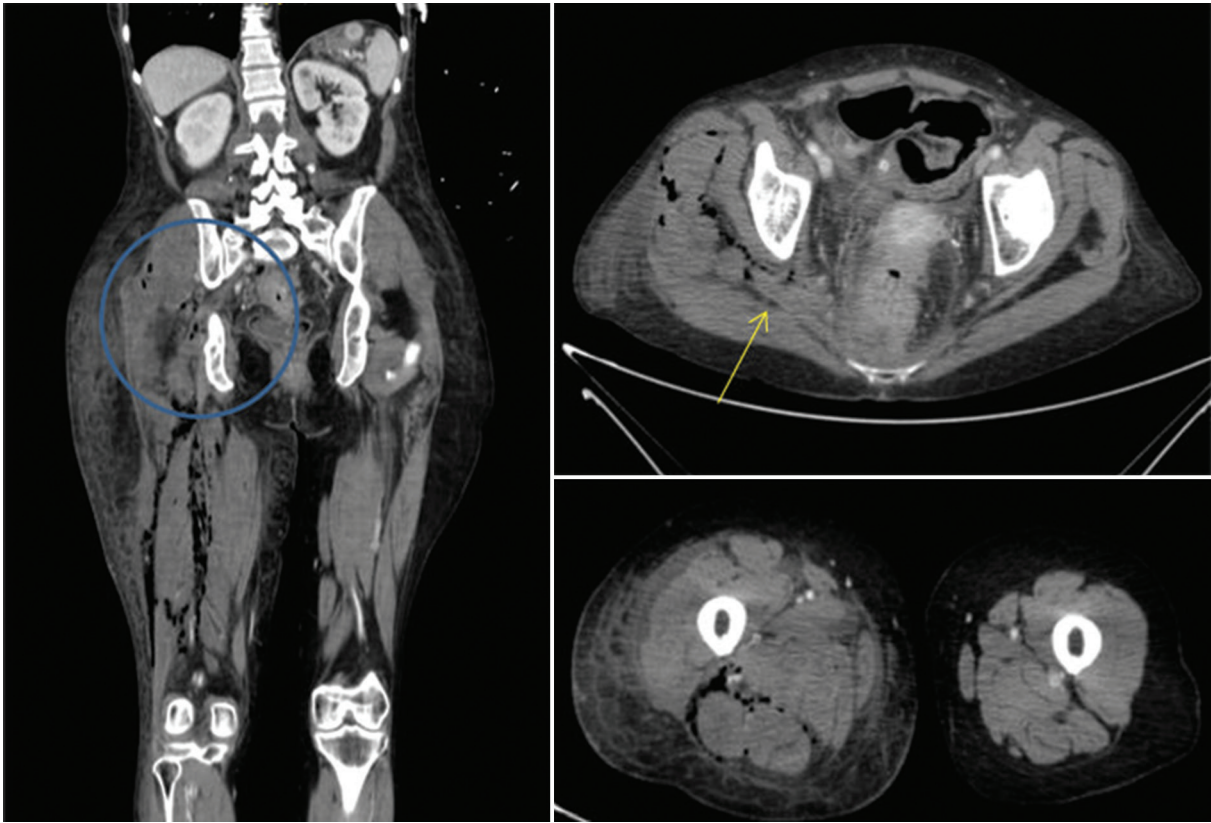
Computed tomography scan of the thigh, demonstrating gas around the left femoral vessels with associated pyomyositis.
